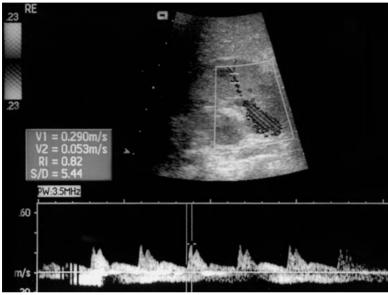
Sonography in haemolytic uremic syndrome (HUS). a Severe thickening of the bowel wall caused by severe E. coli enteritis (extended view sonography with tissue harmonic imaging). b Alteration of renal parenchymal echogenicity in HUS, with duplex Doppler sonography showing elevated RI (RI = 0,82) due to reduced diastolic flow velocity and increased renal vascular resistance
